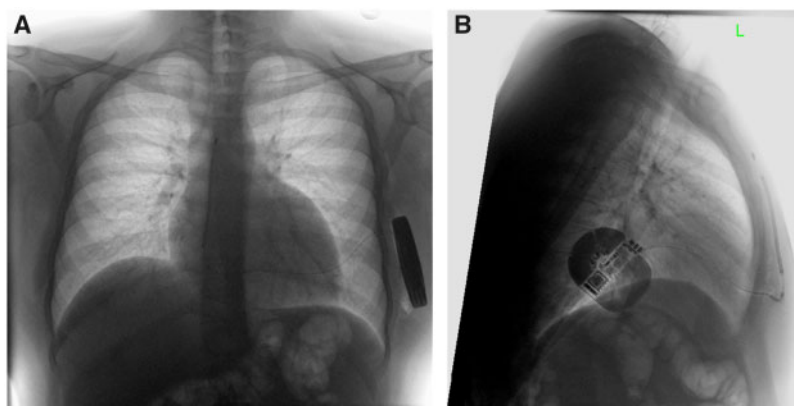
Chest radiograph following device implantation showing correct lead position. (A) PA projection. (B) Lateral projection.
